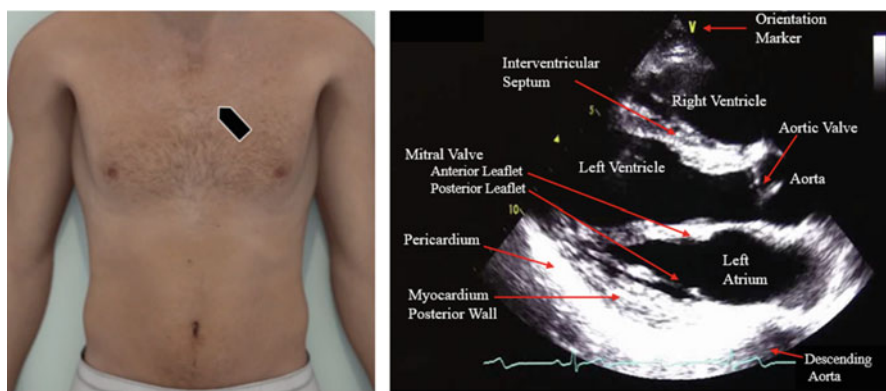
Left panel: placement of ultrasound probe. Right panel: PLAX view with aortic valve closed and mitral valve open
